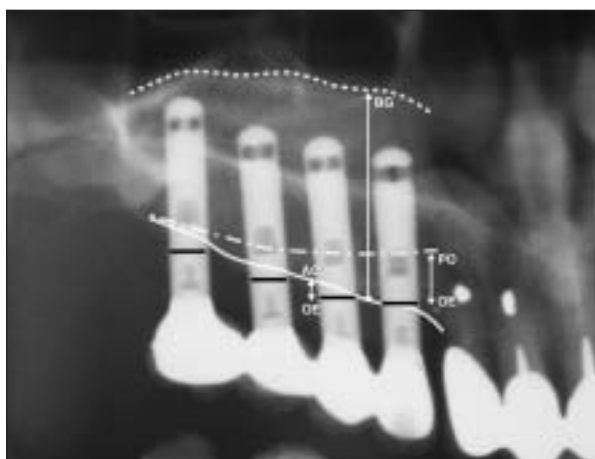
Postoperative panoramic radiograph demonstrating the measured parameters. OE = occlusal edge of the implant; PO = the preoperative sinus floor; BG = the postoperative sinus floor with bone graft; AC = the alveolar crest.
